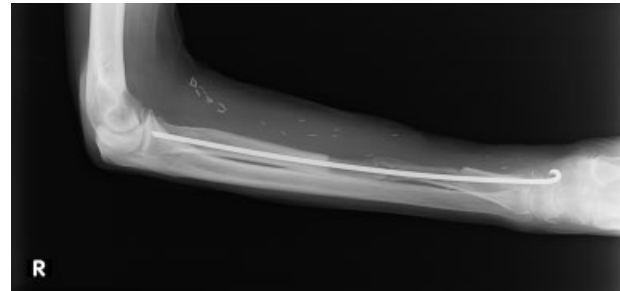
Two months postoperative X-ray of the forearm after stabilization with Rush nail, left lateral projection.
